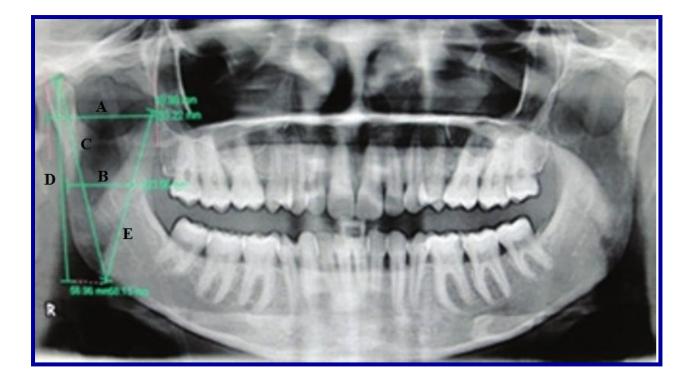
Morphometric measurements on a digital panoramic x-ray (Adapted from Indira et al., 2012)
